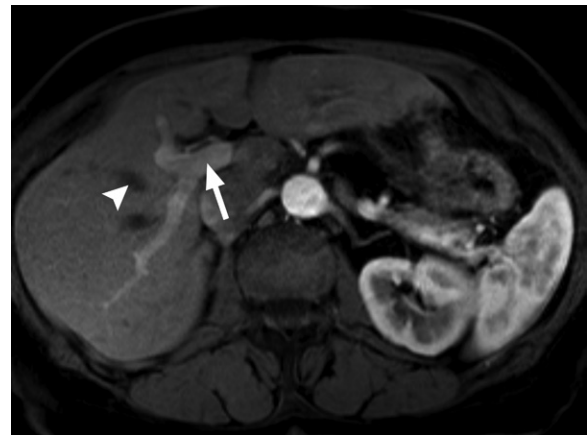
Late hepatic arterial phase timing of postcontrast T1-weighted liver MRI. Axial MR image in the late hepatic arterial phase shows that the portal vein (arrow) is submaximally enhanced, with no contrast enhancement of the hepatic veins (arrowhead). The timing of this acquisition is variable from patient to patient and examination to examination and can be achieved with various methods.
